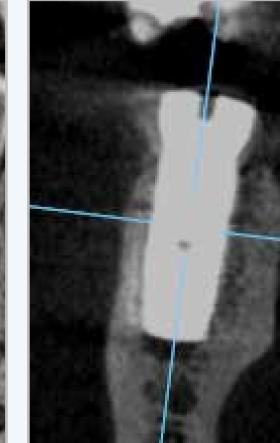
CB-CT at insertion with autogenous bone grafting.
